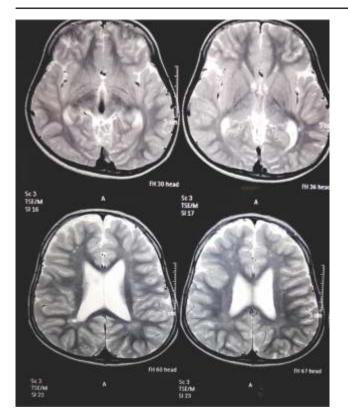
MRI Sections showing Molar Tooth Sign
